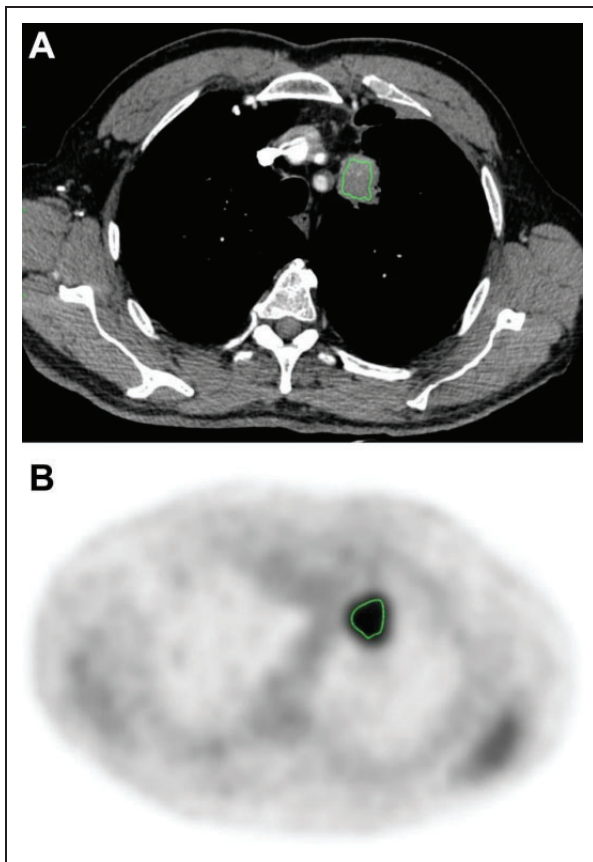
Representative segmentation images for texture analysis. Segmented contrast-enhanced axial CT (A) and Axial FDG PET-CT (B) images of the left upper lobe lung mass in a 65-year-old male. CT, computed tomography.
